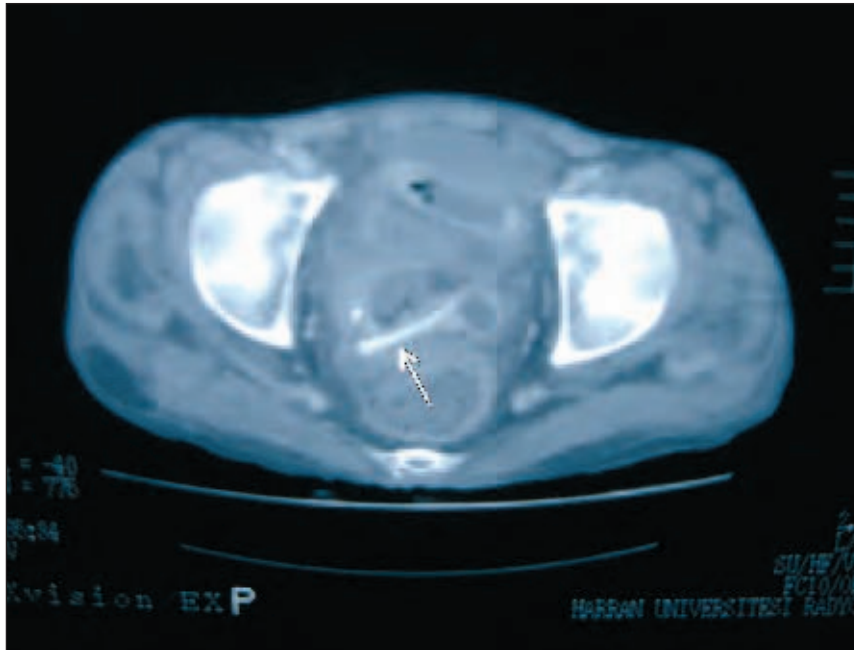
Abdominal CT images of the patient, the arrow is pointing to the foreign body
